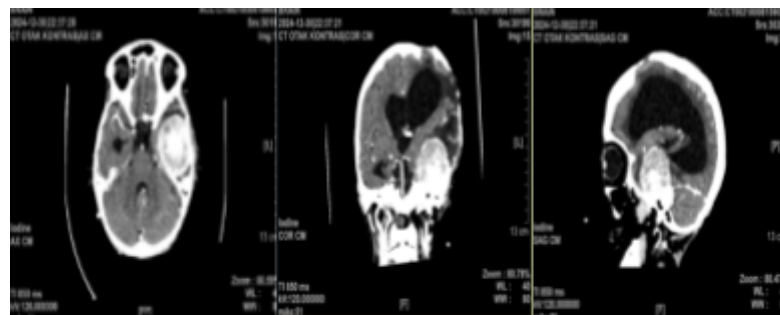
CT brain contrast, December 2024
